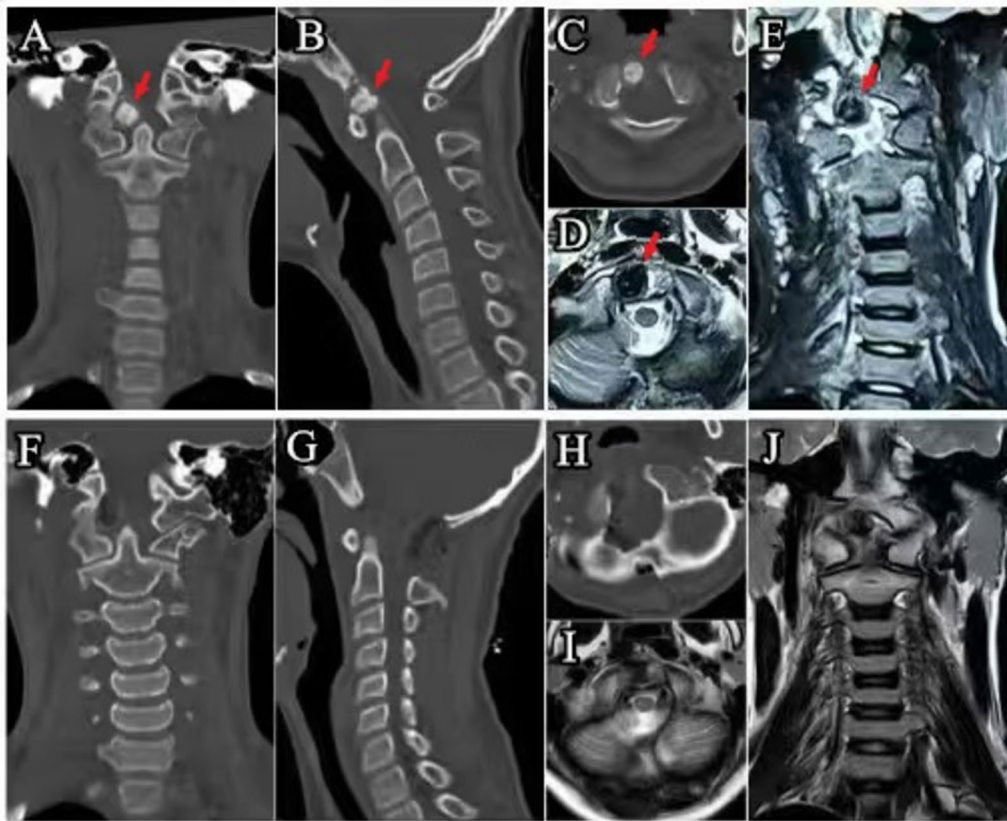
Preoperative imaging data for a patient with osteoid osteoma included CT scans (A–C) and MRI (D–E), which revealed the tumor located in the right occipital condyle. Postoperative CT scans (F–H) and a 3-month postoperative MRI (I, J) indicated satisfactory tumor resection.
